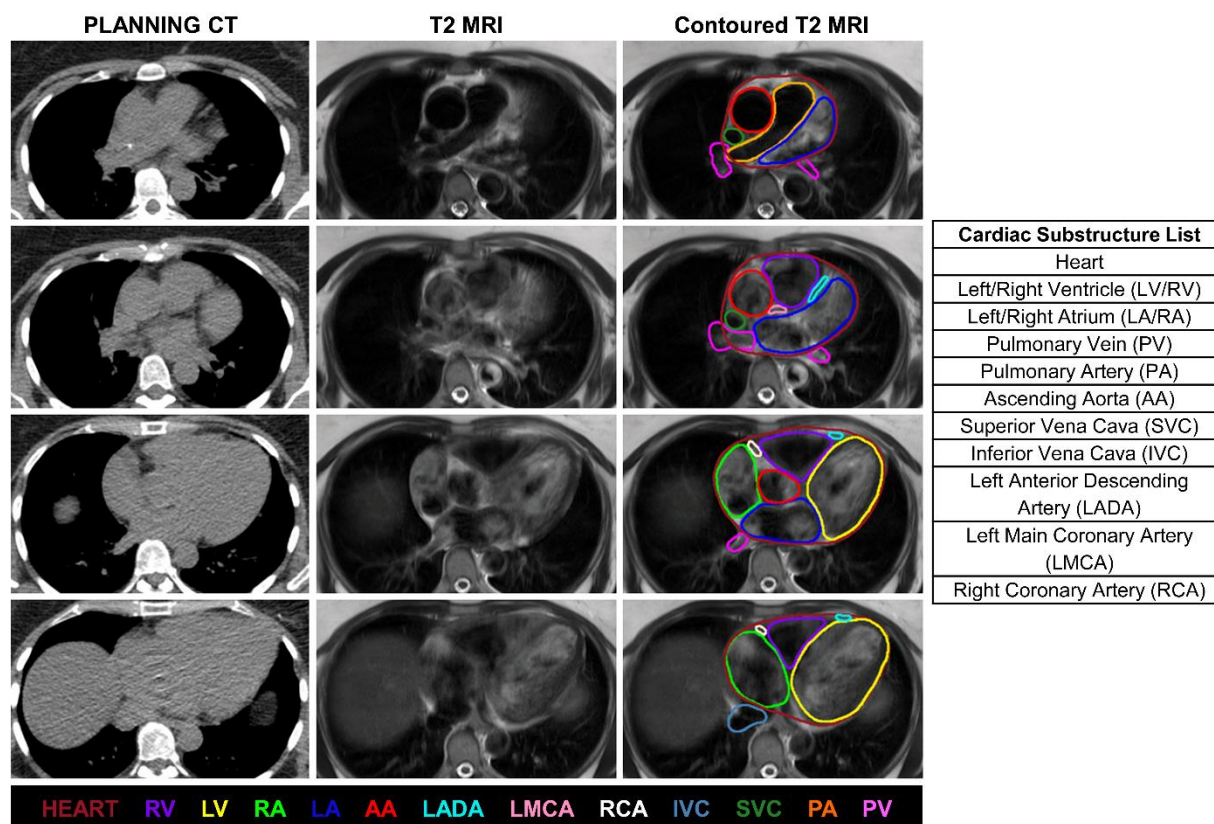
Left: Axial planning CT, axial T2-weighted MRI, and contoured axial T2-weighted MRI, shown at 4 different axial locations. Right: List of cardiac substructures assessed in this study.
